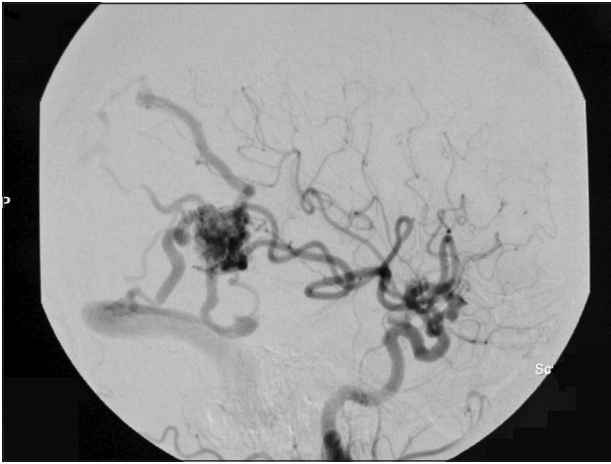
Right common carotid artery angiograms and CTA showing AVM, which is fed by three feeders from the right MCA. Four draining veins are also observed: one is coming to sigmoid sinus, second - to the superior sagittal sinus and two - to the deep cerebral veins.
